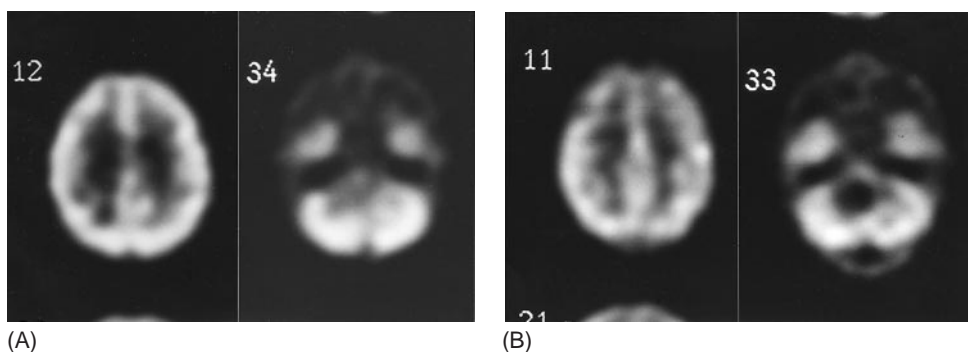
(A) Preoperative ^{99m}Tc -HMPAO SPECT of the brain performed in a 5-year-old right-handed child with a cerebellar medulloblastoma and linguistic deficits. A relative hypoperfusion of the right cerebellar hemisphere is shown. Although there is no breach of the cerebral cortex there is less physiological activation of the left frontal lobe. (B) Postoperative SPECT demonstrates a large scintigraphic defect in the cerebellum slightly off-center to the right. A strikingly increased hypoperfusion deficit in the left frontal lobe is shown.
